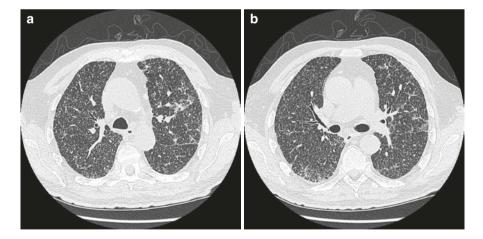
(a) HRCT of the lungs: diffuse, multiple, uniform, and small sharply bounded nodules. (b) HRCT of the lungs: diffuse, multiple, uniform nodules in random distribution. (c) HRCT of the lungs: diffuse, multiple, uniform nodules. (d) HRCT of the lungs (coronal reconstruction): diffuse, multiple, uniform, small sharply bounded nodules in whole lungs
